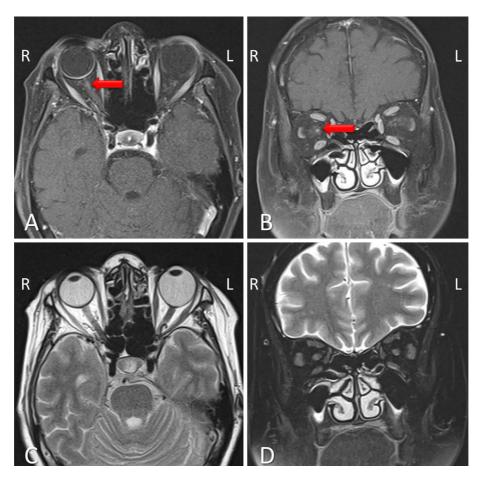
Axial and coronal orbit magnetic resonance imaging (MRI). Post-contrast T1 MRI demonstrates relatively well-marked enhancement of the right optic nerve (arrows) compared with the left optic nerve (A, B). T2-weighted imaging and short T1 inversion recovery show no abnormal signals (C, D).
